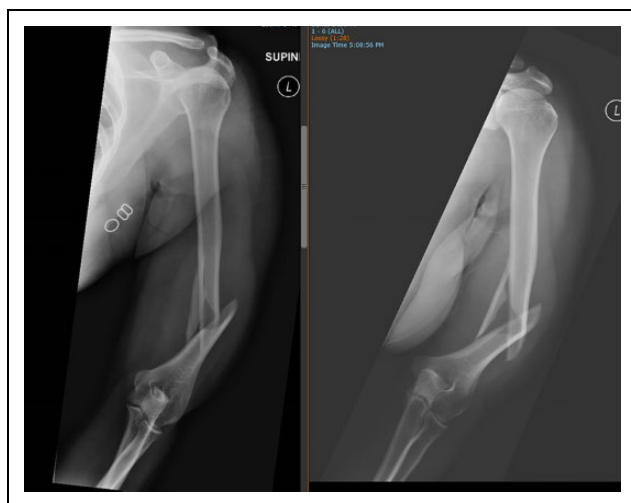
Pre-operative radiograph showing a comminuted humeral shaft fracture.
